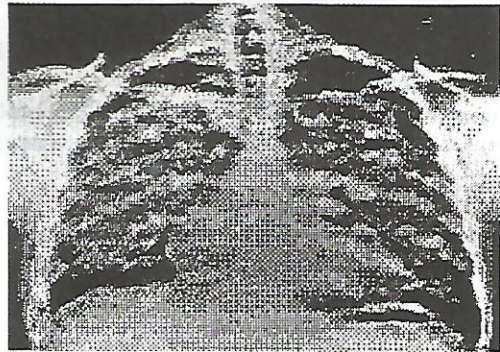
Pulmonary hemorrhage in a 33-year-old man with mitral and aortic stenosis who presented with hemoptysis. Chest radiograph demonstrates extensive bilateral diffuse pulmonary consolidation with sparing of the periphery of the lungs, creating the window frame effect that is suggestive of pulmonary hemorrhage.
